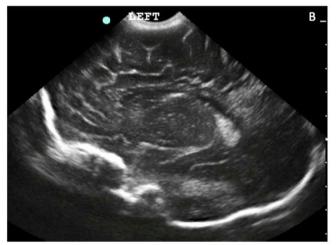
Neuroimaging findings: Cranial ultrasound images from patients with congenital cytomegalovirus at 28 days showing: A sagittal view showing the typical branching linear hyperechogenic lesions of LSV from participant 3 (A); a parasagittal plane over the left ventricle showing periventricular calcifications from participant 2 (B)
